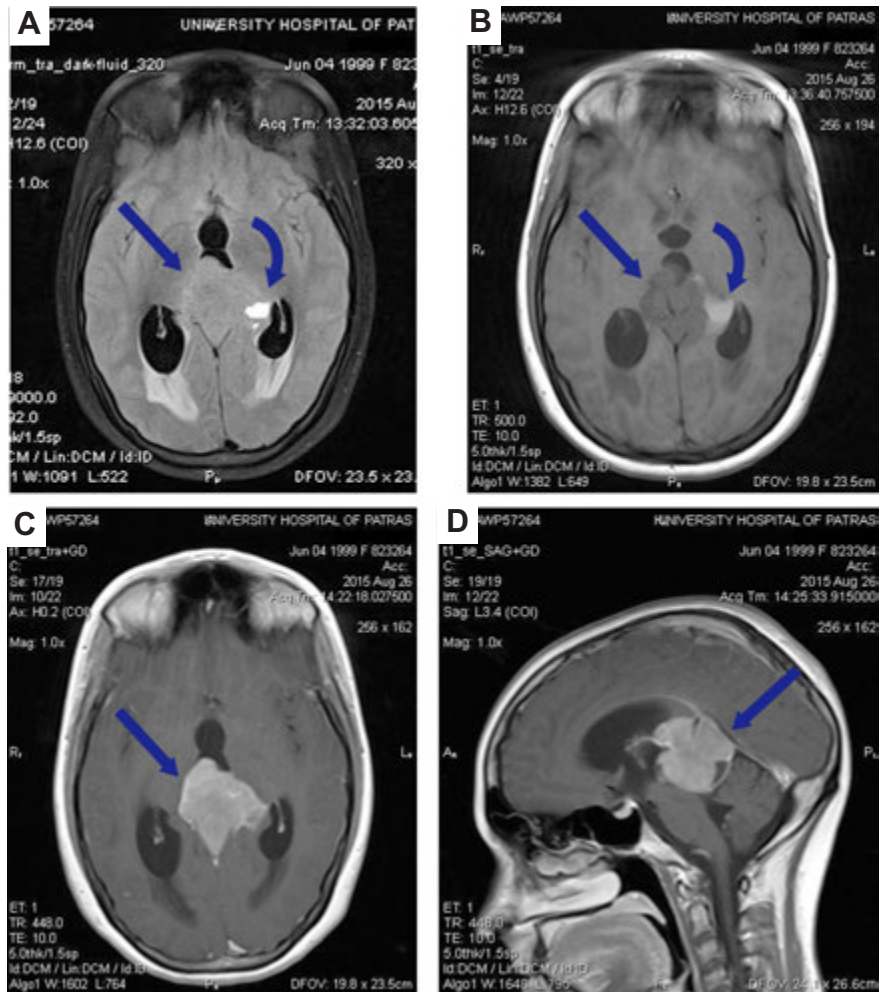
Pineoblastoma in a 16-year-old girl with obstructive hydrocephalus. An ill-defined inhomogeneous pineal tumor (arrow) slightly hypertensive to the adjacent parenchyma on axial FLAIR (A), hypointense on axial T1 SE (B) with hemorrhagic components (curved arrow). Axial (C) and sagittal (D) T1 SE images show the remarkable inhomogeneous enhancement of the tumor (arrow) with infiltration of the internal cerebral veins and the third ventricle resulting in obstructive hydrocephalus.
